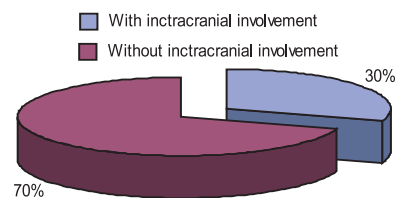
Radiological evidence (CT/MRI) of intracranial extension (n=40)
